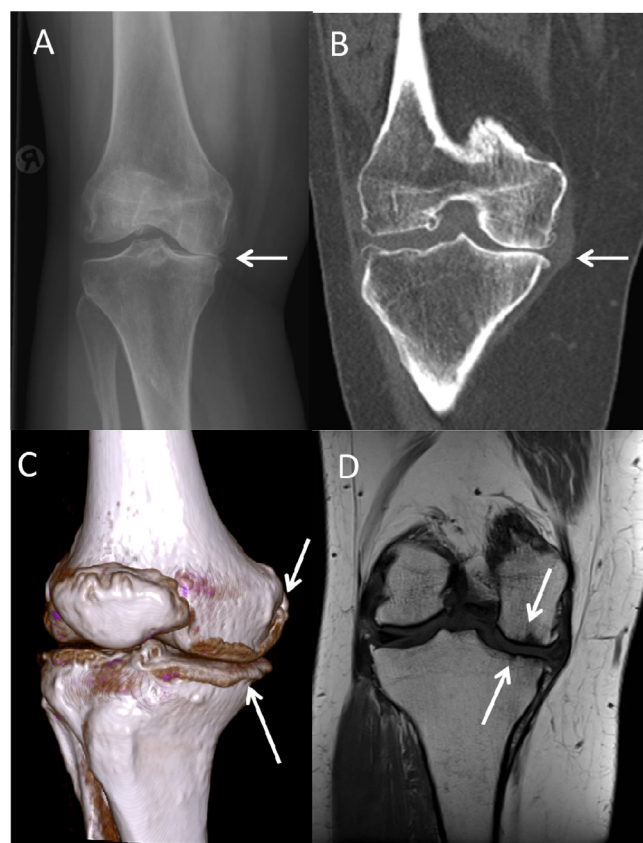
Examples of various imaging technologies used in osteoarthritis (OA) studies, using imaging results of a 57-year-old female with knee OA and a painful and swollen knee. A) Conventional standing semiflexed radiograph of the right knee, showing severe medial knee OA. B) Computed tomography (CT) scan of the same knee, showing in more detail the kissing bone, osteophytes at the medial and lateral joint margins and the tibial eminence as well as subchondral sclerosis and meniscal extrusion (arrow). C) 3D volume rendering of the CT scan, allowing to study the bony morphology in 3D. It becomes apparent that osteophytes are made up of a bony rim enlargement from the edges of both tibia and femur (arrows). D) Coronal T1 weighted magnetic resonance imaging without fat saturation of the same knee, now also showing small hypointense bone marrow lesions in the medial femur and tibia (arrows).
